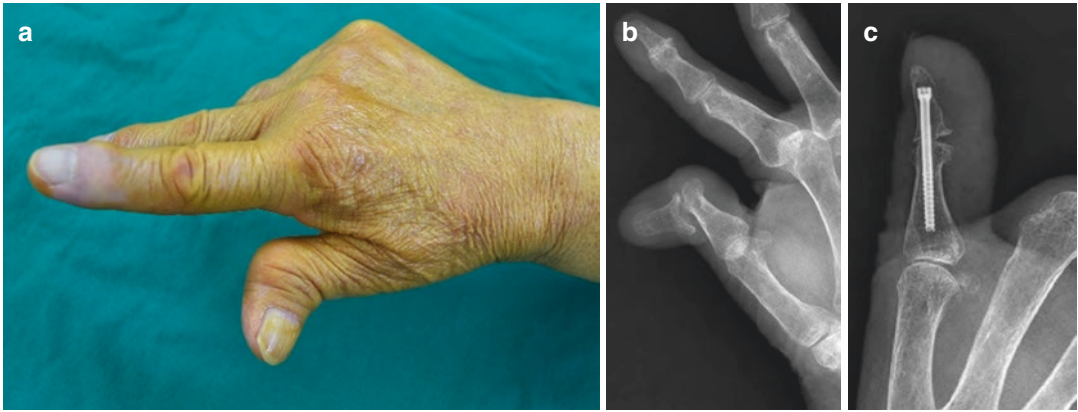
A 68-year-old female patient with joint deformity due to rheumatoid arthritis (a). Preoperative (b) and post-operative radiographs (c) after arthrodesis using headless screws
